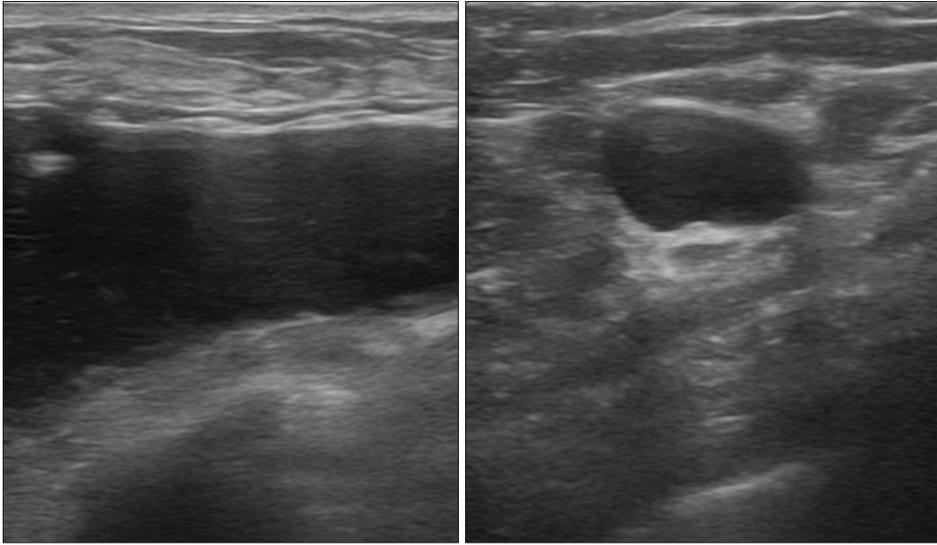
The intraoperative color Doppler ultrasound image of breasts with scattered distribution of polyacrylamide hydrogel (PAHG). Because of the hydrophilic property, PAHG presents the image characteristics of low echo under real-time ultrasound exploration. Therefore, PAHG is shown as liquid dark areas or encapsulated cysts in the ultrasound images.
